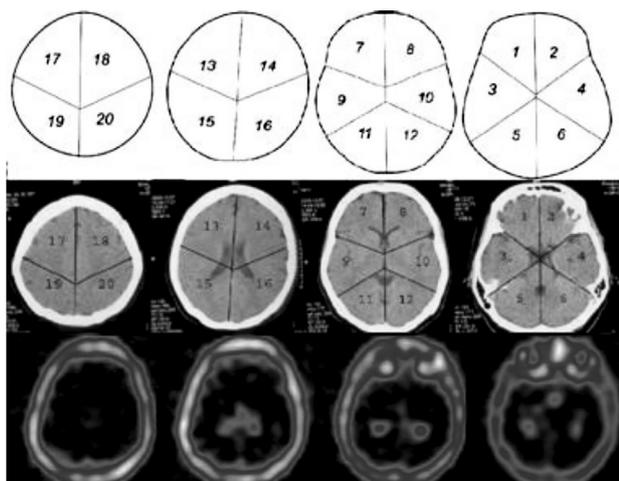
^{99m}Tc -MIBI single-photon emission computed tomography scan images divided into 20 segments according to the anatomical landmarks seen on computed tomography and single-photon emission computed tomography scans
